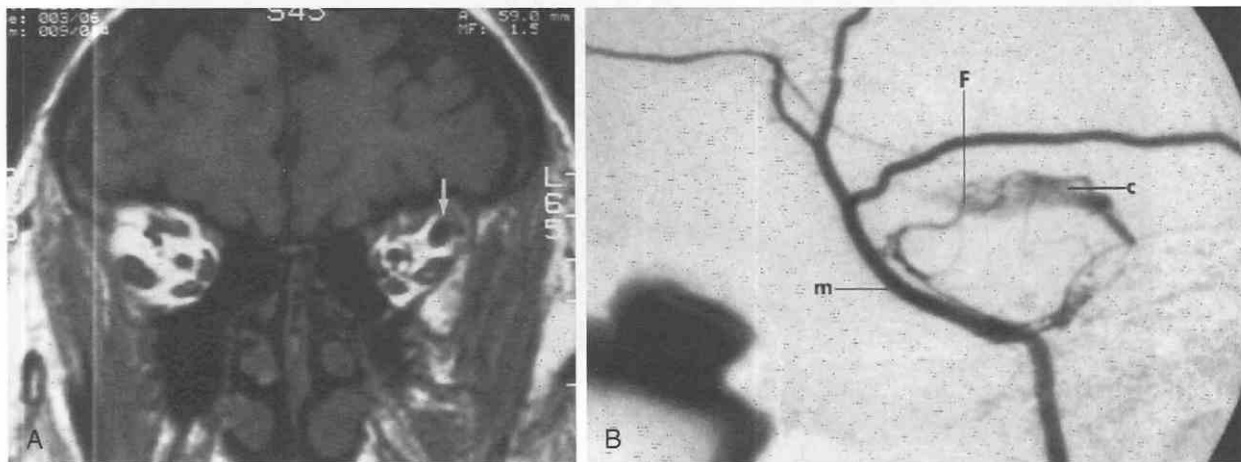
Carotid cavernous fistula. *A*, Coronal T1-weighted MRI study shows marked enlargement of the left superior ophthalmic vein (arrow). *B*, Lateral digital subtraction angiogram shows fistulous communication between branches of the external carotid and the cavernous sinus. m, middle meningeal artery; F, fistula; c, cavernous sinus.
